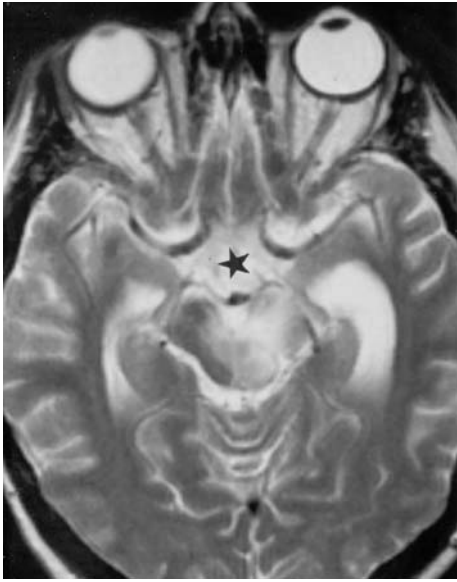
MRI of a 40-year-old man with a progressive visual deficit followed by loss of consciousness. Diagnosis: tuberculous meningitis. MRI: a Axial T2-weighted view at the level of the anterior commissure, demonstrating bilateral infarction of the basal ganglia in addition to enlargement of the supratentorial ventricles (indicating CSF disturbance). b Corresponding T1-weighted, contrast-enhanced view visualizing inflammatory infiltration of the entire basal cisterns. c Coronal, T1-weighted, contrast-enhanced view also showing complete casting of the basal cisterns with encasement of the chiasm and vessels
